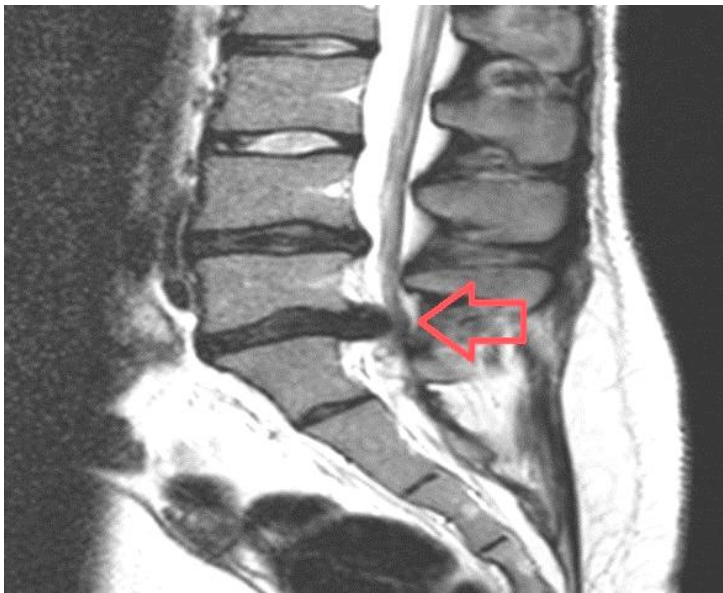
MRI scan of the lower back showing a prolapsed disc
